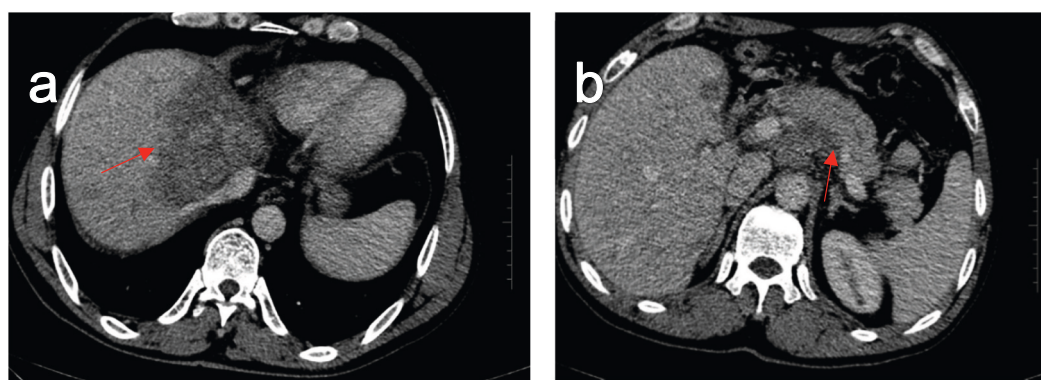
CT scan of the entire abdomen showing fusion and enlargement of multiple nodules in the residual liver (a) and enlarged necrotic retroperitoneal lymph nodes with compression of the pancreas (b).
